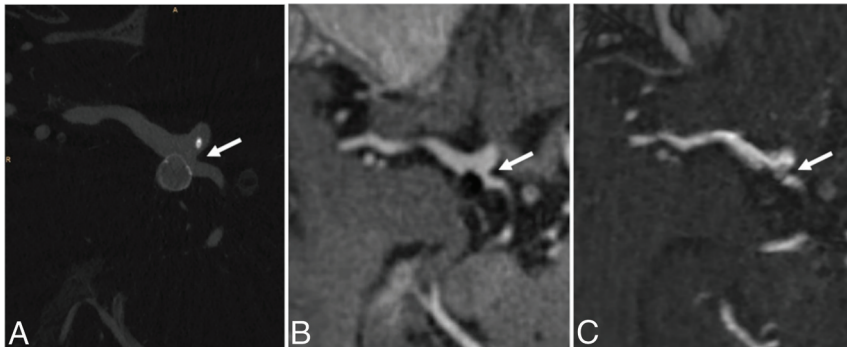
A PcomA aneurysm treated with the WEB. The origin of the PcomA is well-visualized in flat-panel detector CT with an intra-arterial contrast injection (A, arrow) and UTE-MRI (B, arrow). In TOF-MRA with contrast (C), the WEB detachment zone creates an artifact that does not allow clear visualization of the PcomA origin (arrow).
